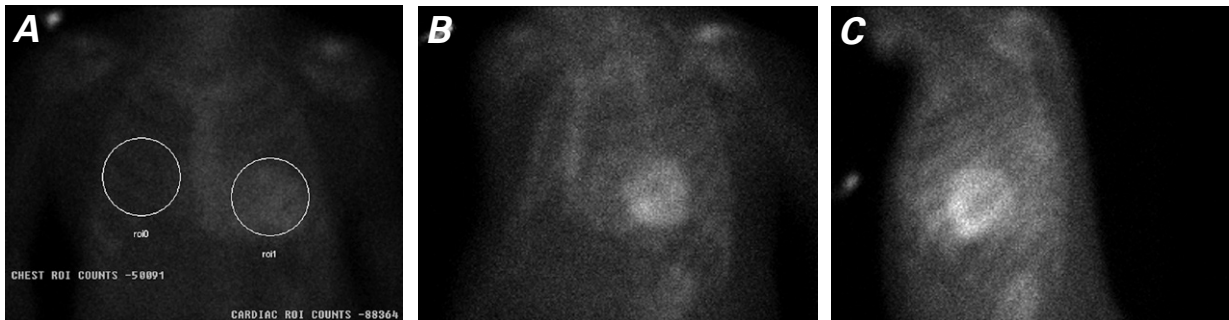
Nuclear scintigrams obtained in the A) anteroposterior, B) left anterior oblique, and C) left lateral views, 4 hours after injection of 21.4 mCi of technetium-99m pyrophosphate, show greater uptake of the radiotracer in the heart (roi1) than in the contralateral lung (roi0) (ratio, 1.76). The 4-hour delay in imaging was due to renal insufficiency.
